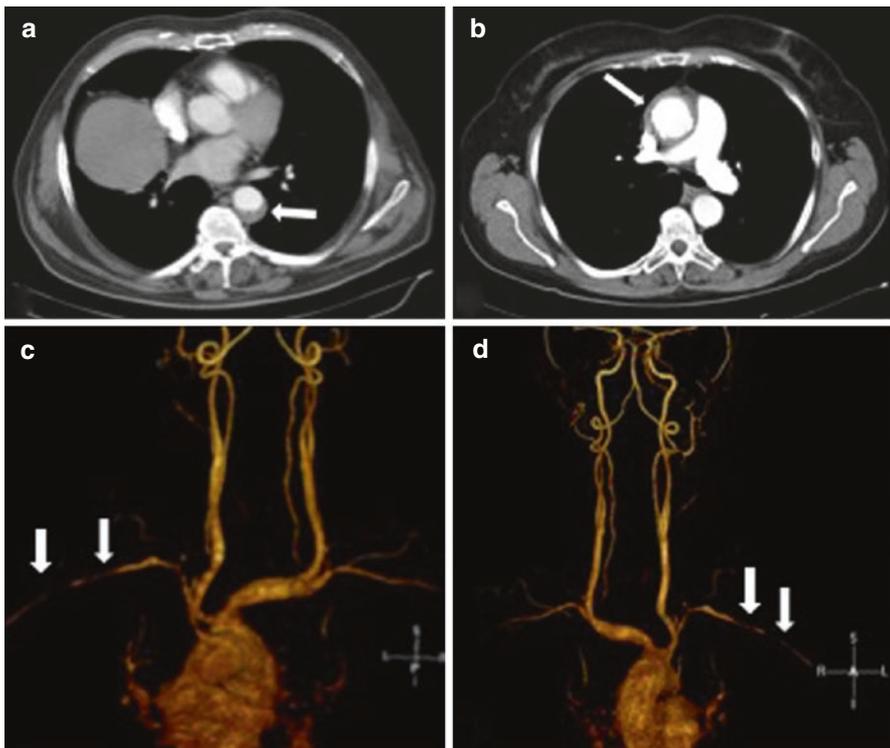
(a, b) Computed tomographic (CT) appearance of thoracic periaortitis. The perivascular tissue surrounds (a) the upper portion of descending aorta (*arrow*), and (b) the ascending thoracic aorta (*arrow*). (c, d) Magnetic resonance (MR) angiography of thoracic periaortitis with epi-aortic artery involvement. The scans show diffuse caliber reduction of the right subclavian artery (*arrows*) (c) and significant caliber reduction of left subclavian artery (*arrows*) (d).
